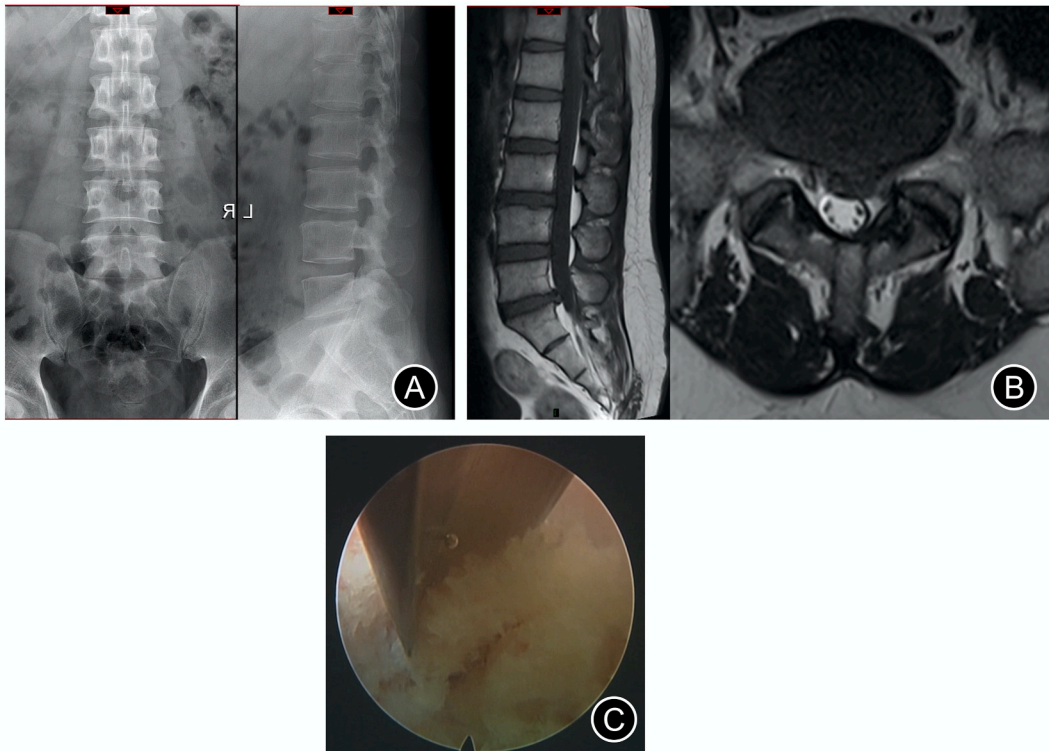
Imaging results for a 42-year-old male patient who underwent PELD (L5/S1). (A) X-ray images of lumbar vertebrae at anteroposterior and lateral positions showing L5/S1 disc herniation. (B) T1-weighted sagittal (left) and T2-weighted axial (right) preoperative magnetic resonance images of the lumbar spine showing L5/S1 disc herniation. (C) Partial ventral facetectomy was performed using a trephine reamer.
